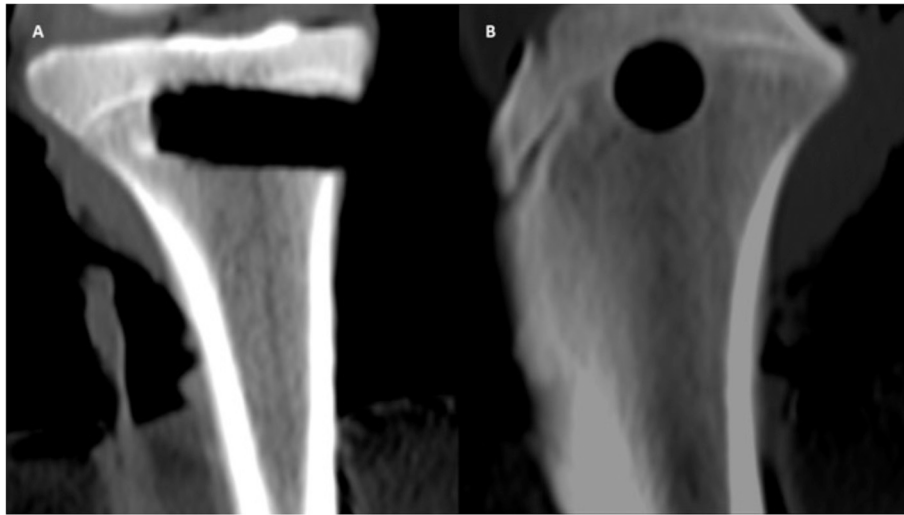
The CT scans after the fatigue test showed an intact bone, without any sign of deformation of the critical-size defect (A: coronal plane, B: sagittal plane).
